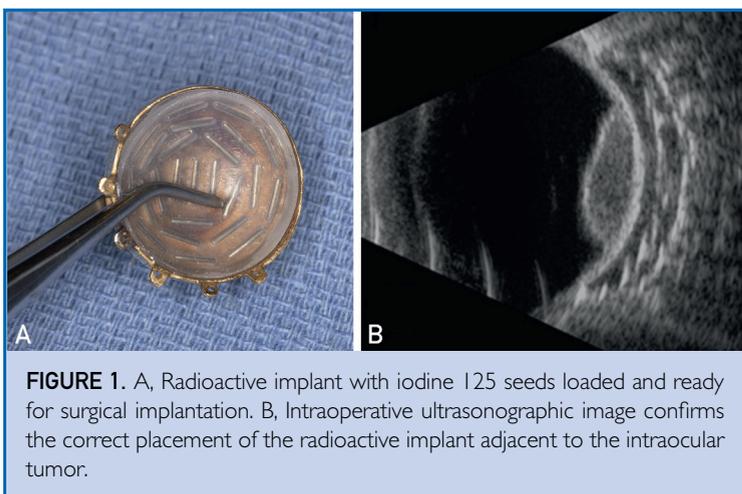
A, Radioactive implant with iodine 125 seeds loaded and ready for surgical implantation. B, Intraoperative ultrasonographic image confirms the correct placement of the radioactive implant adjacent to the intraocular tumor.
